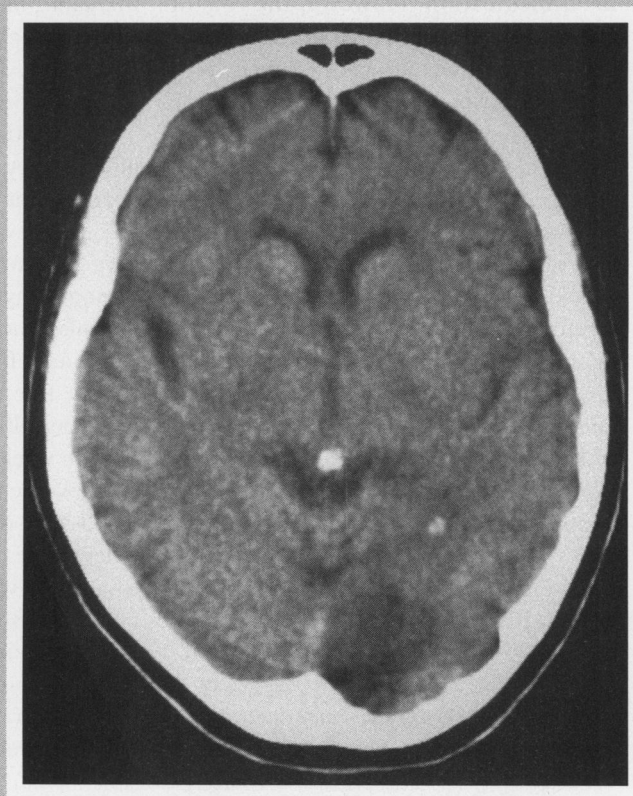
Higher CT cut from case 2: Homogeneously enhanced lesion in the left parietal lobe is unrelated to the infarct in the occipital lobe. The lesion is typical of a meningioma.
